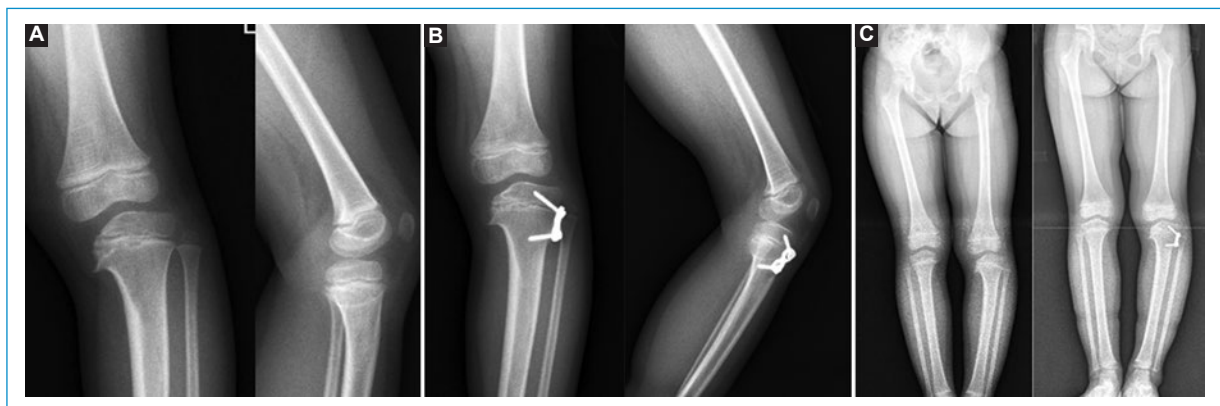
Plain knee X-Ray of a patient with blount disease, treated with emiepiphysiodesis using reconstruction-plate. A: before surgery. B: at seven months follow-up. C: comparative scanogram (courtesy of Maharjana MA).
